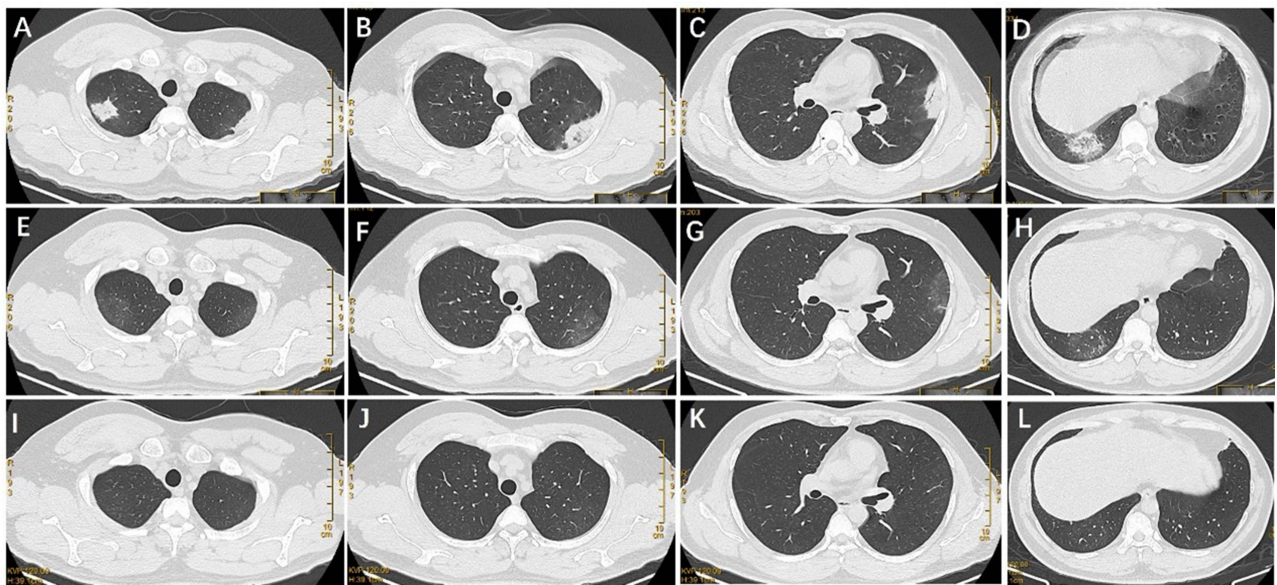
Chest computed tomography (CT) images of the patient. Chest CT on admission showing bilateral pneumonia (A–D). Chest CT after 2 weeks of treatment showing improvement in the bilateral pneumonia (E–H); Chest CT after 4 weeks of treatment showing complete resolution of the lung changes (I–L).
